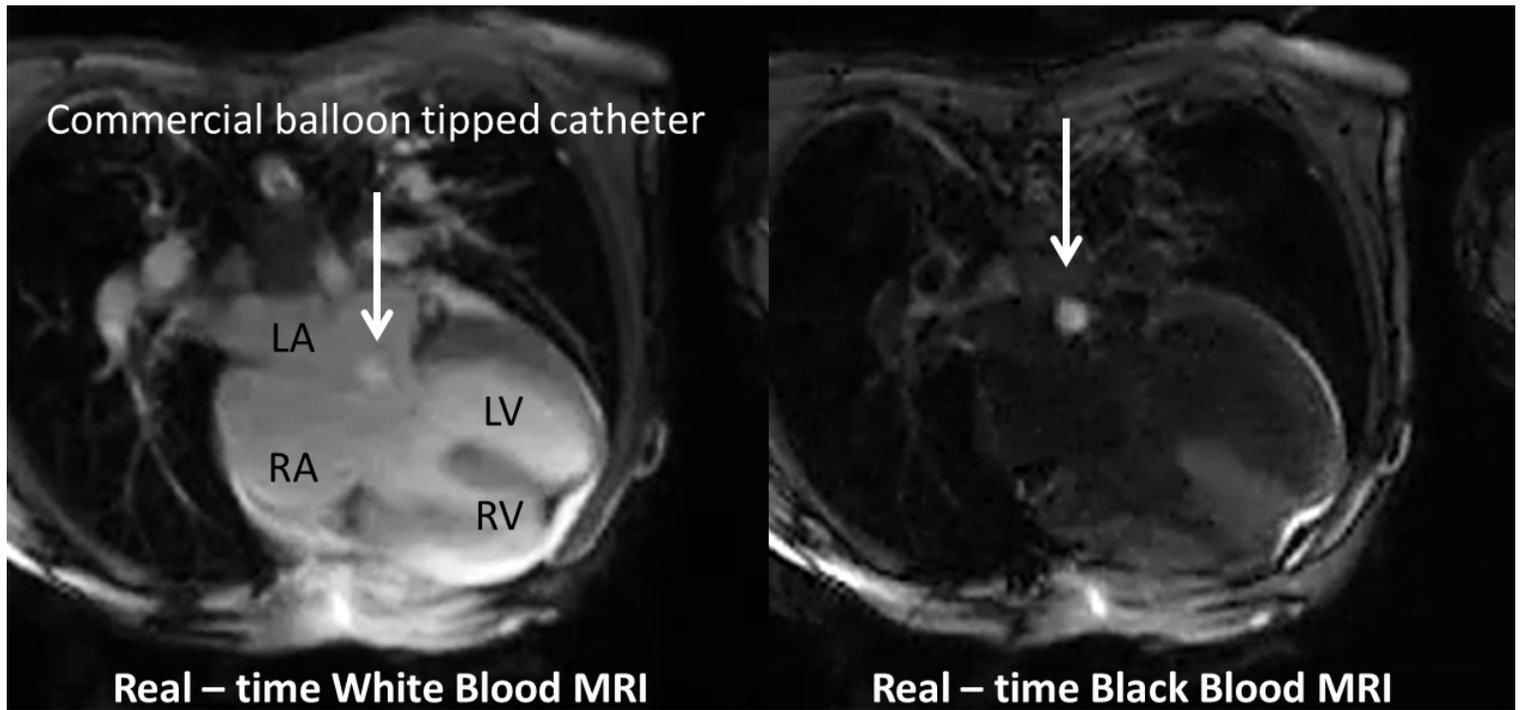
Real-time MRI Right and Left Heart Catheterization in Complete Atrioventricular Canal.
